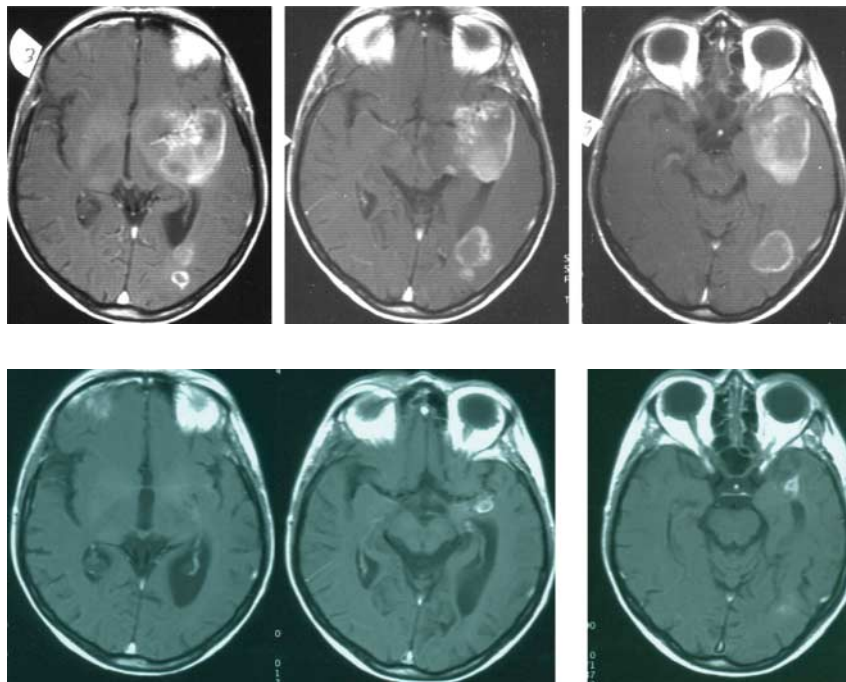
a): MRI study of a 52-year-old female patient with a lesion of $6 \times 5 \times 4$ cm in the left frontal region, and a mass in the left parietooccipital region measuring $4 \times 3 \times 3$ cm diagnosed as glioblastoma multiforme in June 2002 (Pretreatment MRI, -T1, Gadolinium contrast).
